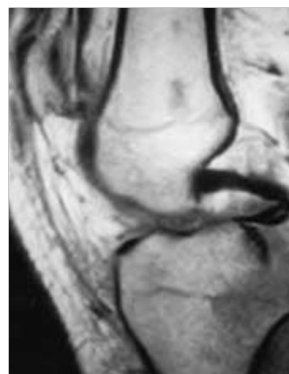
MRI showing PCL avulsion from tibial attachment
